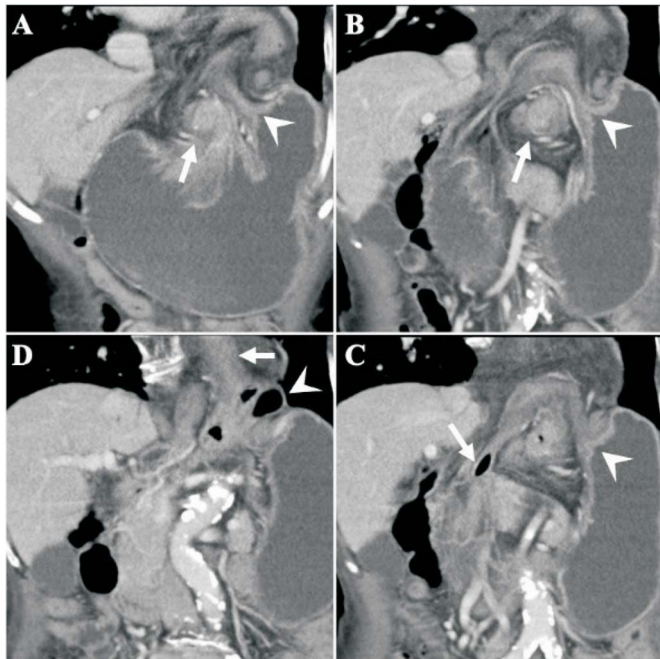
Contrast-enhanced computed tomography (CT) images of the patient. (A to D) Anterior-posterior contrast-enhanced CT images in the coronal view: (A, B) the stomach appears upside-down with the pylorus (arrowhead) located in the left upper abdomen and is superior-anterior to the gastroesophageal junction (arrow); (C) the pylorus (arrowhead) connects to the duodenum (arrow) and across the gastroesophageal junction anteriorly; (D) the upper part of the stomach bulges through the diaphragm indicating hiatal hernia (arrowhead) and the esophagus (arrow).
